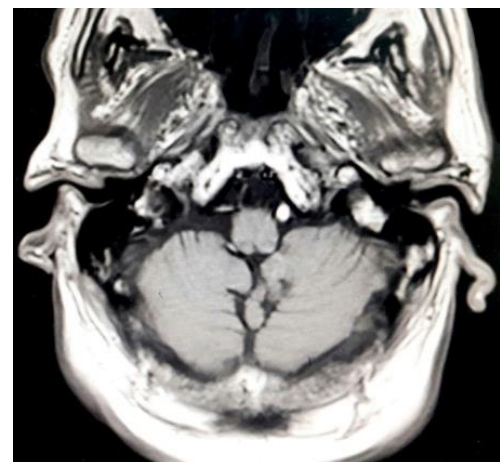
MRI T1 scan (in 2020) for the brain which shows the beginning and the diameter of the basilar artery at the ponto-medullary junction.
